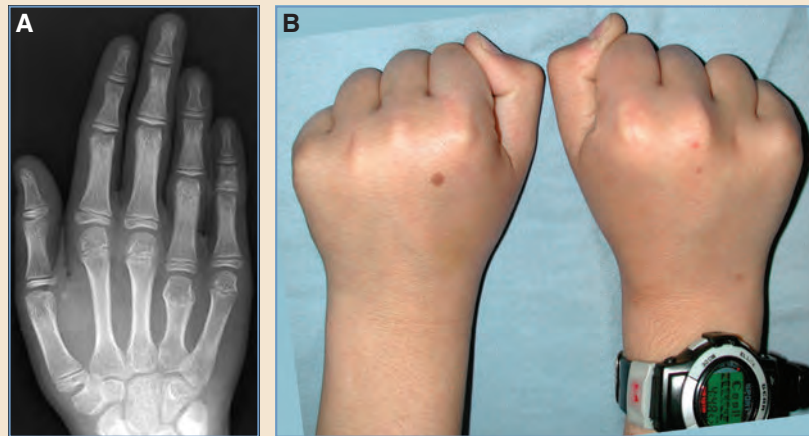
Bilateral metacarpal hypoplasia most pronounced in the right fourth metacarpal, but also affecting the third metacarpal and the left hand to a lesser extent. A, Posteroanterior radiograph of the right hand. B, Clenched fists showing the marked right fourth brachymetacarpia.
